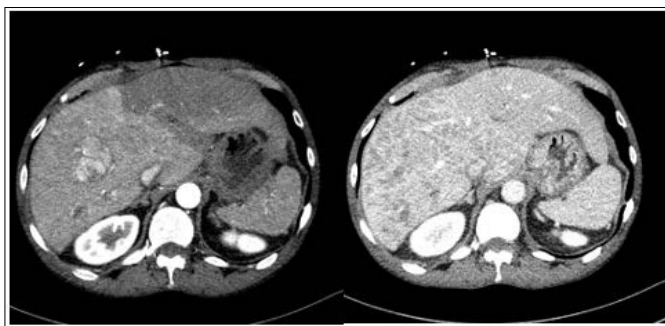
CT with Arterial and Venous Phase Demonstrates an Arterially Enhancing Mass in Segment 7/8 with Washout
